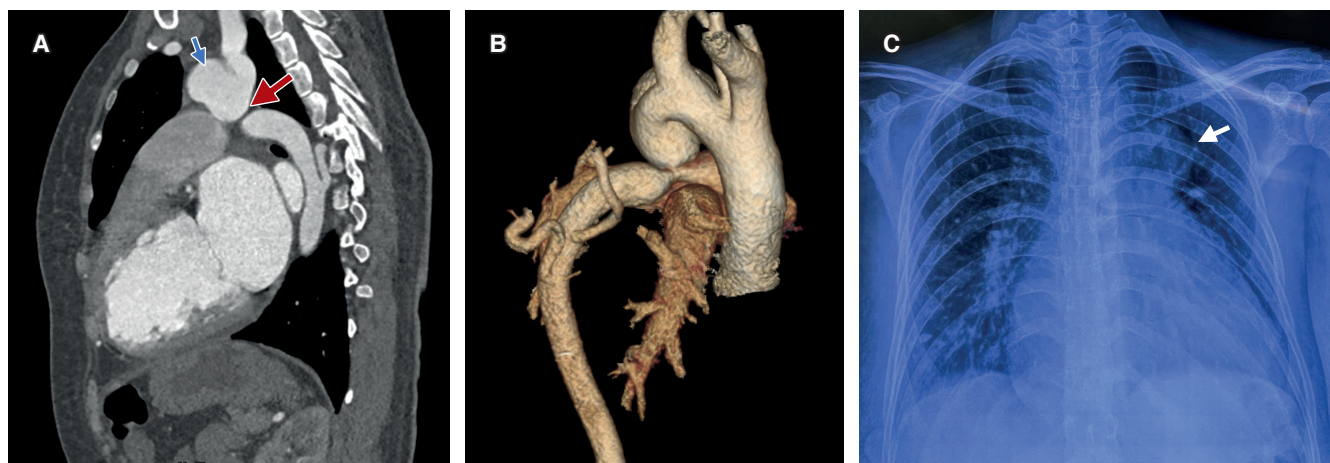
A) Sagittal CT scan showing aneurysm (blue arrow) and interruption of the aortic arch (red arrow). B) Reconstruction of great vessels. C) Preoperative chest X-ray showing a huge mass (white arrow).
